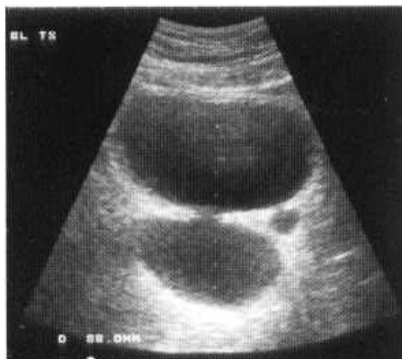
Transverse ultrasound image of the bladder showing two posterior-lying diverticula.
